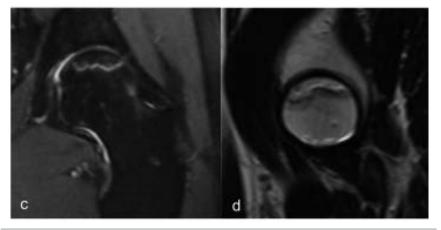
Based upon radiographic assessment, the amount of AVN may be uncertain (a,b). In contrast, MRI clearly depicts the necrotic area (c,d).
